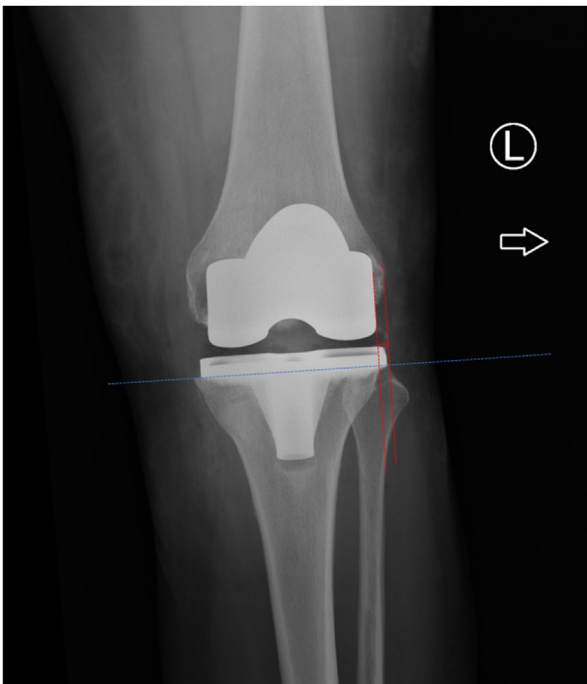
Radiographic measurement tibial component overhanging (AP).
